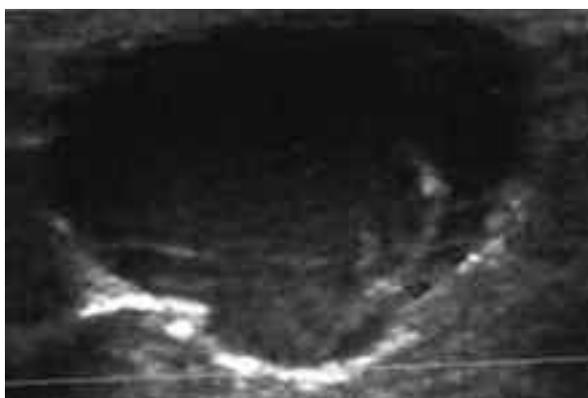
Ultrasound Doppler showed an increase up to 25 mm in the maximum diameter of the lesion and the presence of multiple septa covered by a rich plait of collateral vessels (age of 13 years).
